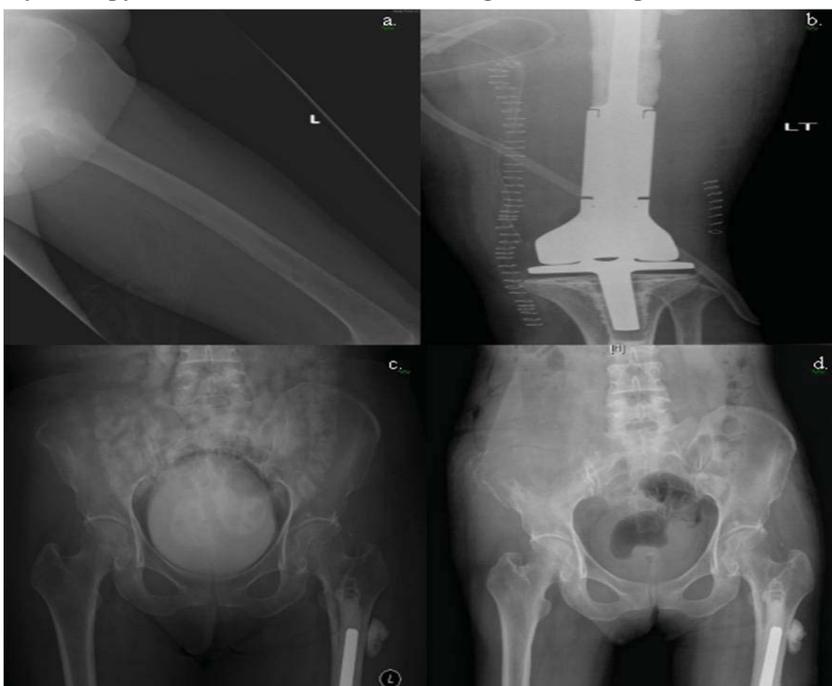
(a). Lytic lesion seen in the distal femur. Fig. 3(b). Megaprosthesis. Fig. 3(c). Lytic lesion right iliac wing. Fig. 3(d). Post cryotherapy radiograph of pelvis showing tumour destruction.
